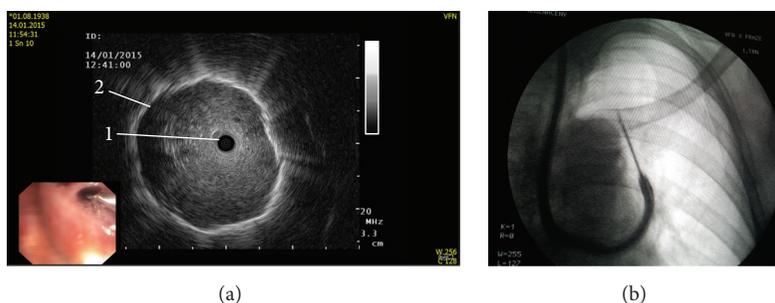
Endobronchial ultrasound-navigated lung biopsy. (a) Bronchoscopic and ultrasound image, (1) bronchus, and (2) external border of the tumor. (b) X-ray control of the procedure.
